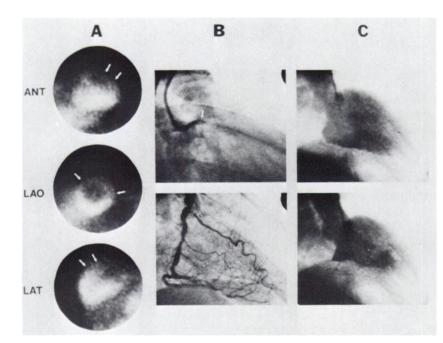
(A) Abnormal TI-201 scintigram in patient with severe coronaryartery disease, showing diminished perfusion of anterolateral and high posterolateral walls (arrows). (B) Coronary arteriograms in RAO view, showing total occlusion of main left coronary artery (arrow) and diffuse, severe right coronary lesions. (C) End-diastolic (upper) and end-systolic (lower) frames of left ventriculogram showing severe hypokinesis of antero-lateral wall. (Abbreviations as in Fig. 1.)
